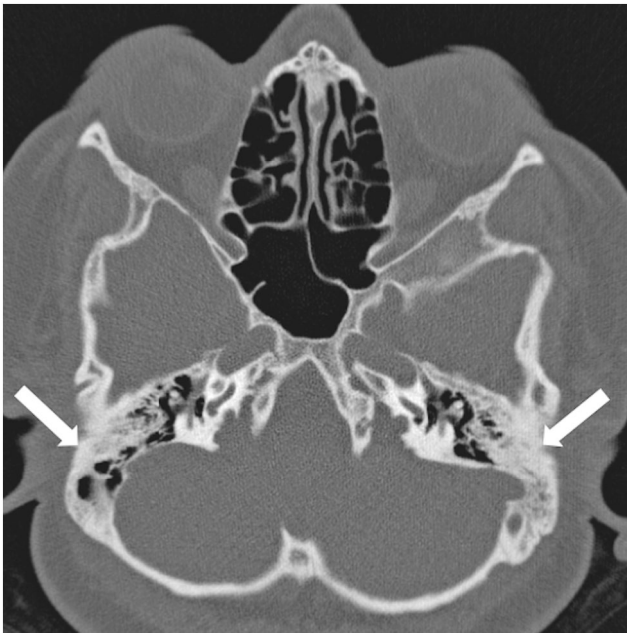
Poor development of mastoid air cells in the same 14-year-old boy as in Fig. 4. Axial CT image demonstrates the poor mastoid aeration (*arrows*)
